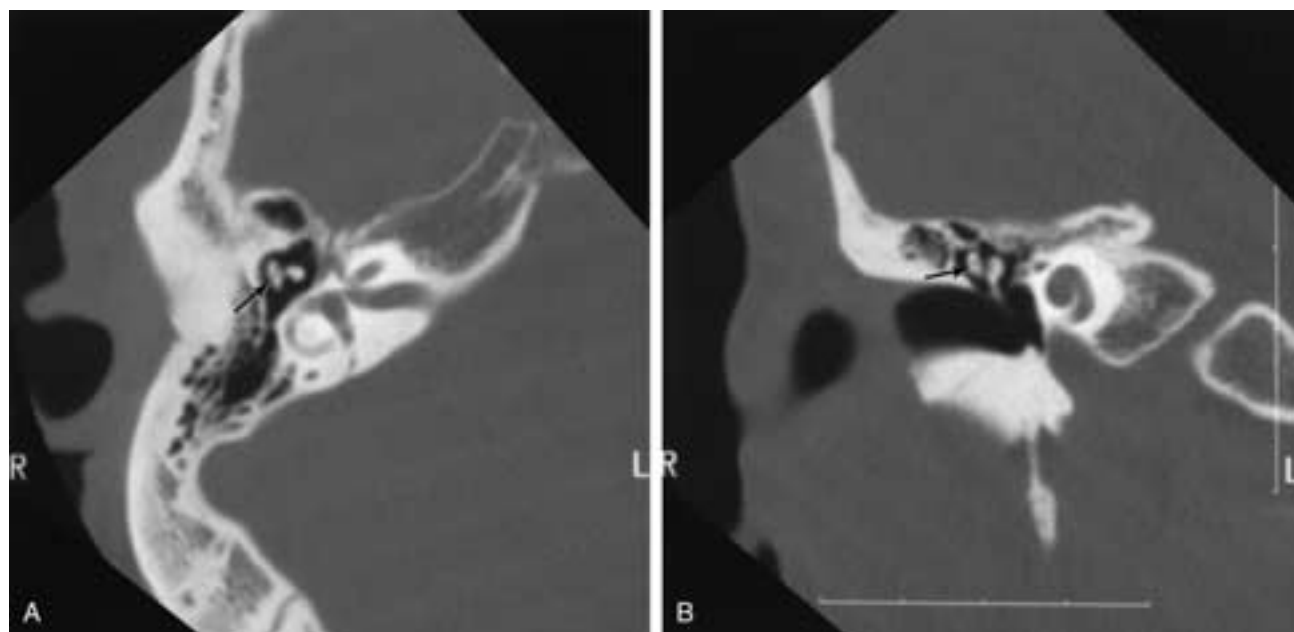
Incus dislocation. A, Magnified axial CT image, right ear. The incus (*arrow*) is dislocated and positioned lateral to the malleus head. B, Magnified coronal CT image, right ear. The anterolaterally dislocated incus (*arrow*) is not normally seen at the level of the malleus, creating a so-called Y configuration. See the text. (Courtesy of Dr. F. Veillon)
